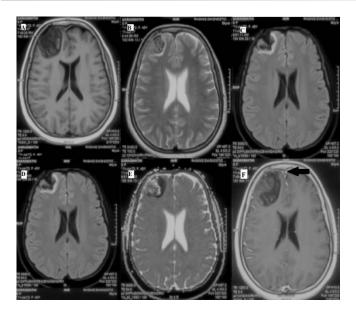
A-T1 weighted image showing mixed intensity lesion with predominant hyperintensity with specs of hypo-intensity, B&C- T2& flair showing mixed intensity lesion with hyperintense rim, D&E-Diffusion weighted image showing diffusion restriction & Apparent diffusion co-efficient showing corresponding hypointensity, F- contrast enhanced MRI showing filling defect in anterior part of superior sagittal sinus.
